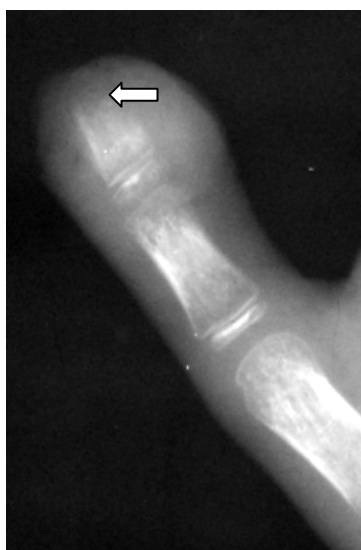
Radiograph of the first finger of the hand. Osteoporosis, consolidation and increase in soft tissues in area of distal phalanx is indicated. It is destruction of a bone of distal phalanx of the first finger (arrow). Panaricium of the first finger of the hand
